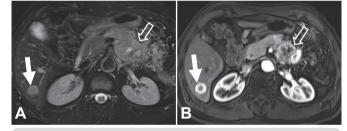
Hypervascular metastasis. Hepatic nodule (arrow) slightly hyperintense on T2-weighted image (A) with intense rim enhancement (arrow) on arterial phase of dynamic study (B), proved to be a metastasis. The primary tumor is depicted in the body/tail of pancreas (open arrow).
